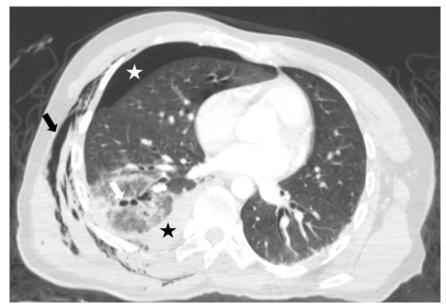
A 30-year-old male with blunt thoracic trauma after a fall from height. Axial CT image showing traumatic pulmonary pseudocyst (white arrow), subcutaneous emphysema (black arrow), pneumothorax (white asterisk) and hemothorax (black asterisk).
